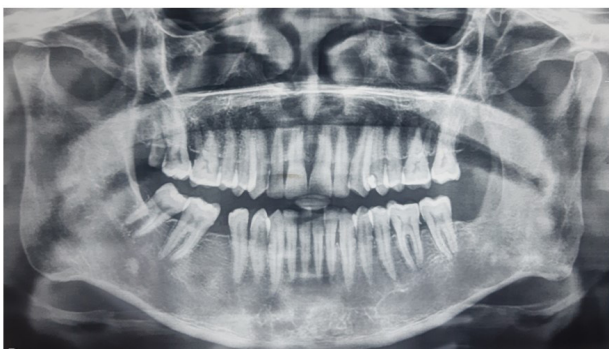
Five years post-operative pantomogram showing complete ossification of bone, no radiographical signs of recurrence can be seen.
